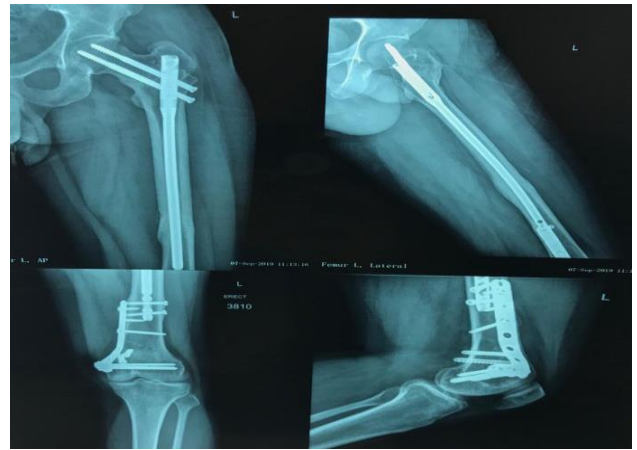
24 months follow up x-ray showing united trifocal fracture of femur, with implants *in situ*, AP and lateral view.
